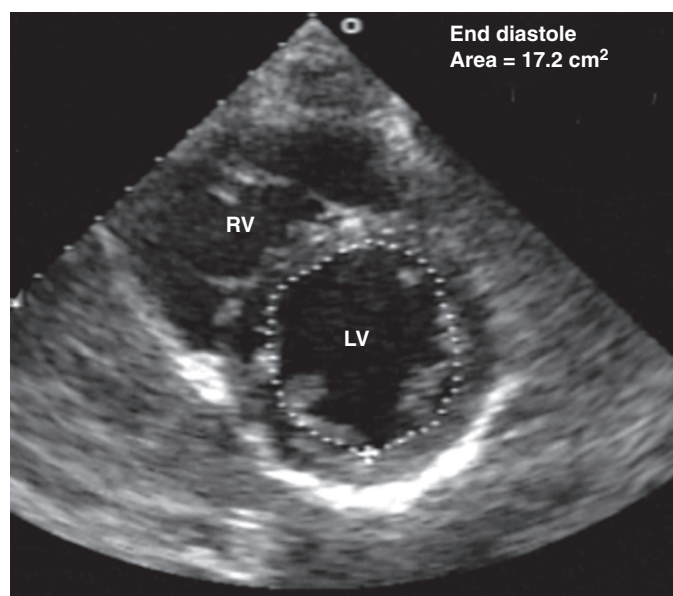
■ Calculation of left ventricular end-diastolic area in the transthoracic short-axis view at the level of the midpapillary muscle by endocardial contour tracing. Values of normal left ventricular end-diastolic area in the short axis range from 9.5 to 22 cm².¹⁵ The level of the midpapillary muscle is used because of the reproducibility of the view and because changes in left ventricular volume affect the short axis of the ventricle to a greater degree than the long axis. LV, left ventricle; RV, right ventricle.
